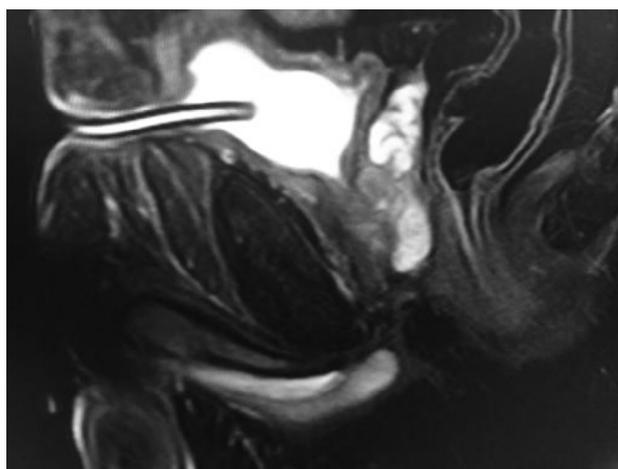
T2-weighted magnetic resonance image of the pelvis on empty bladder with pelvic fracture urethral injuries.
